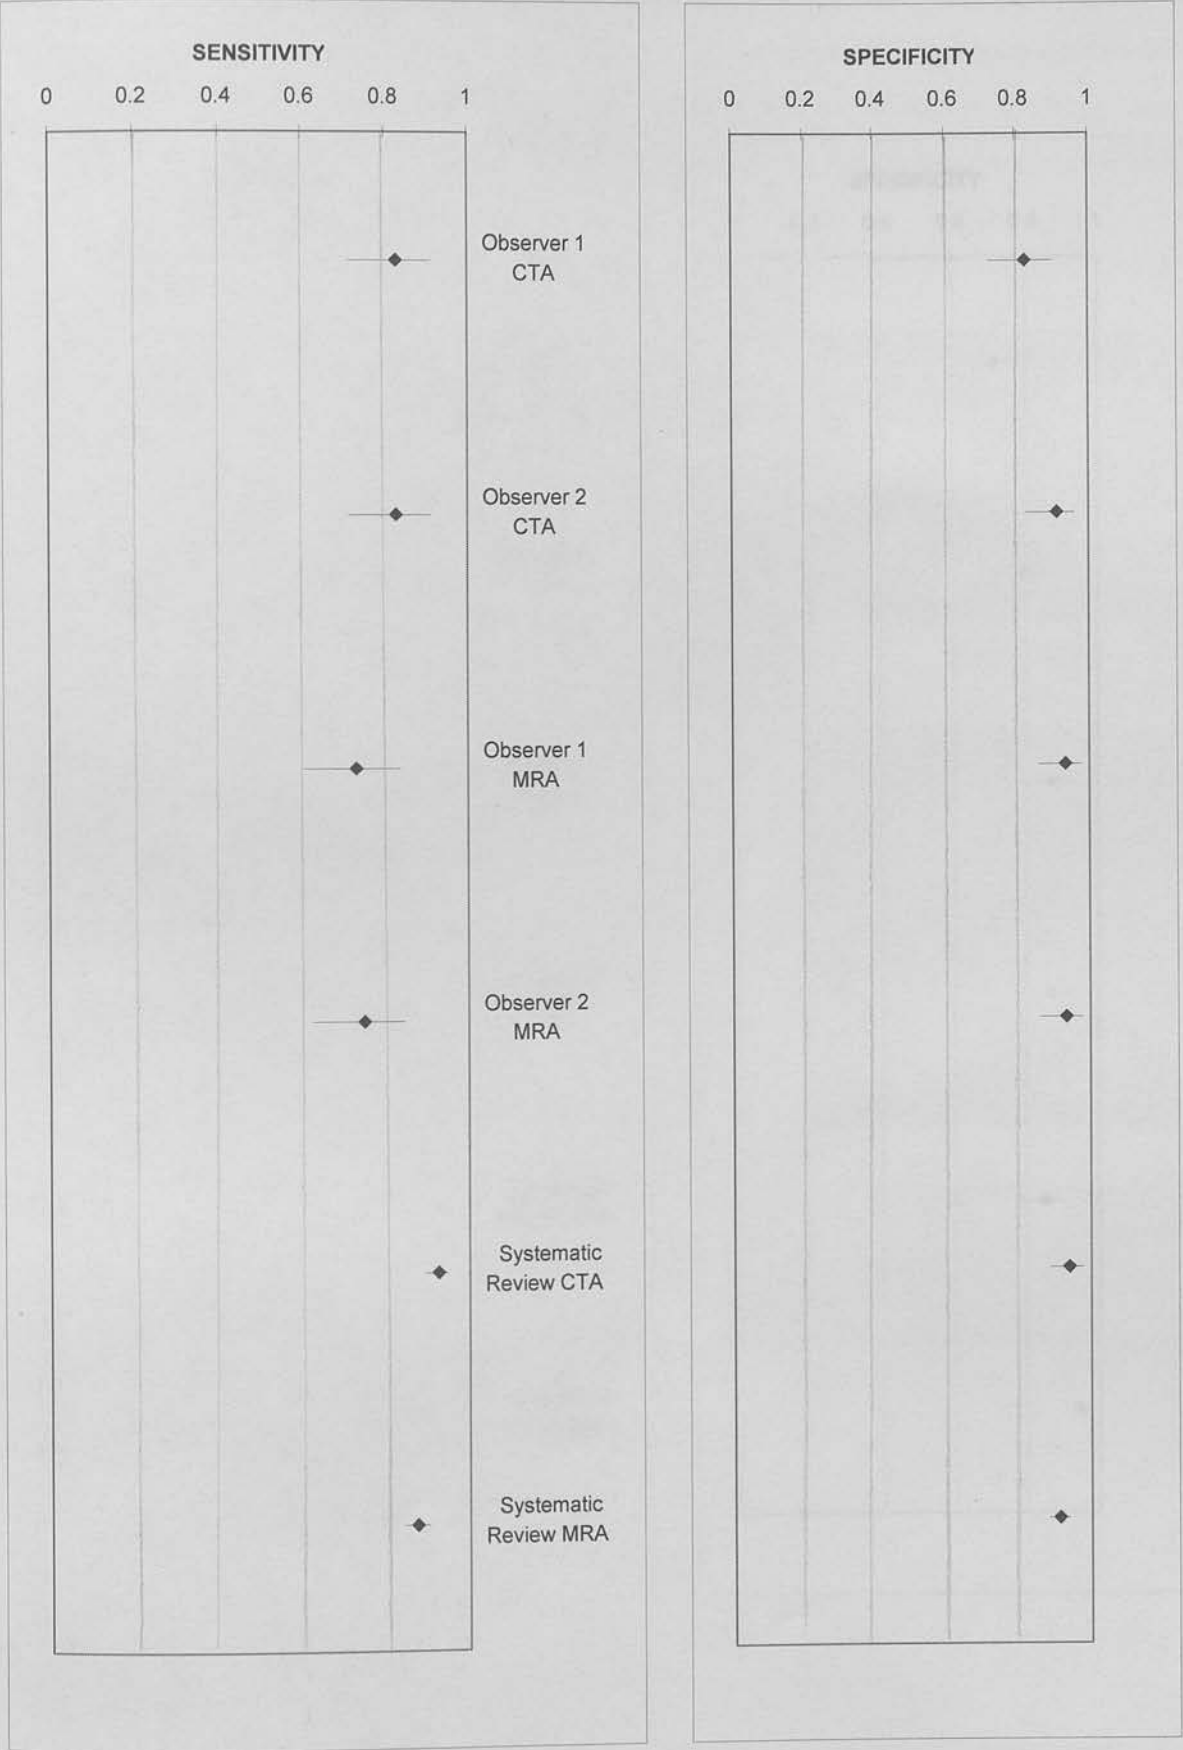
Forrest plots of sensitivity and specificity for CTA and MRA per aneurysm
